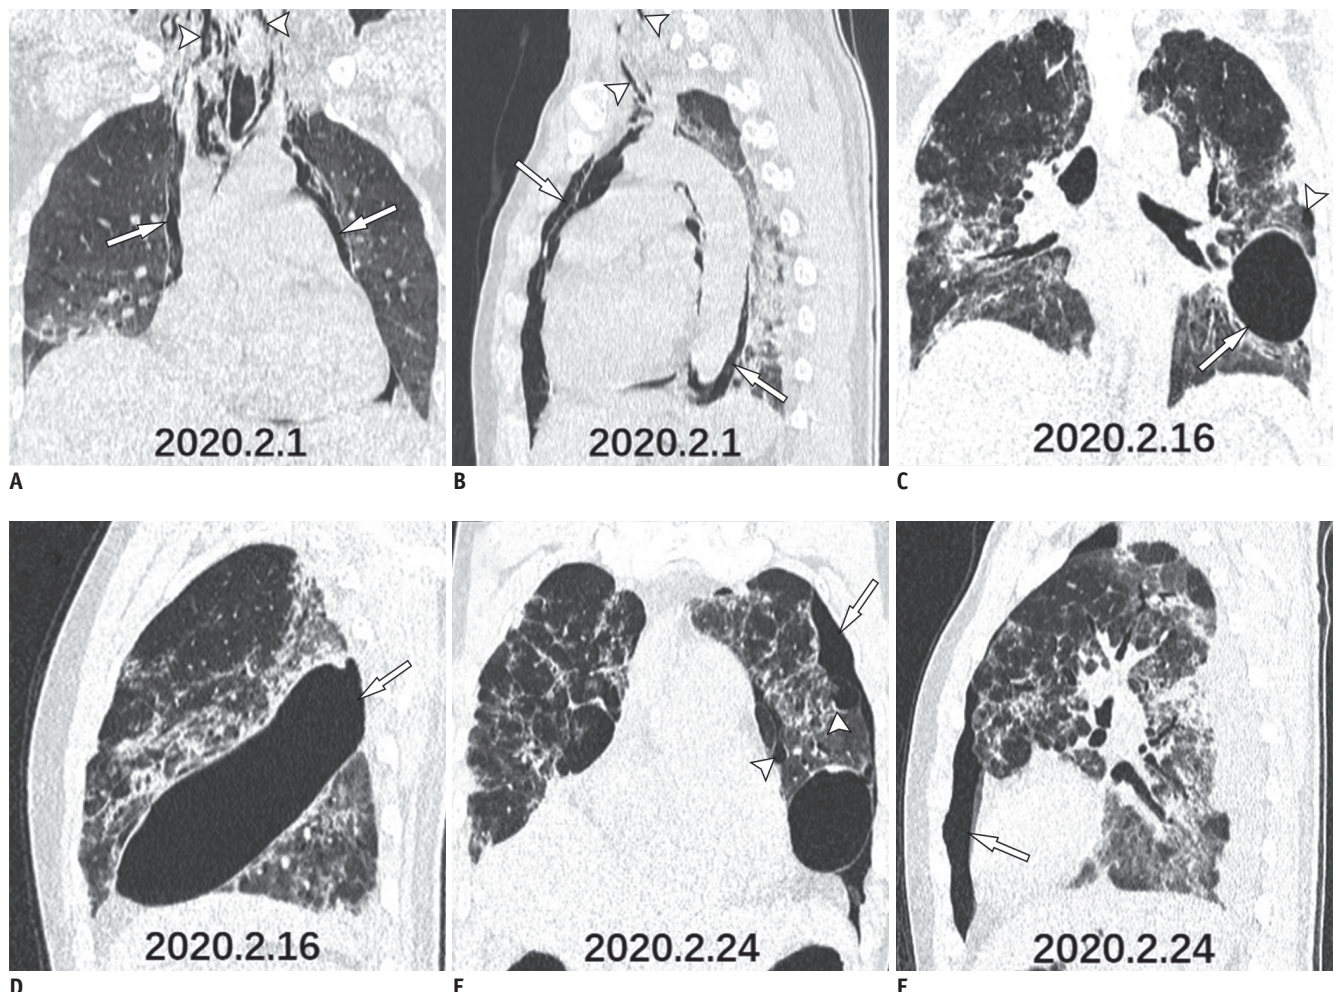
Coronal and sagittal thin-slice chest CT images.
